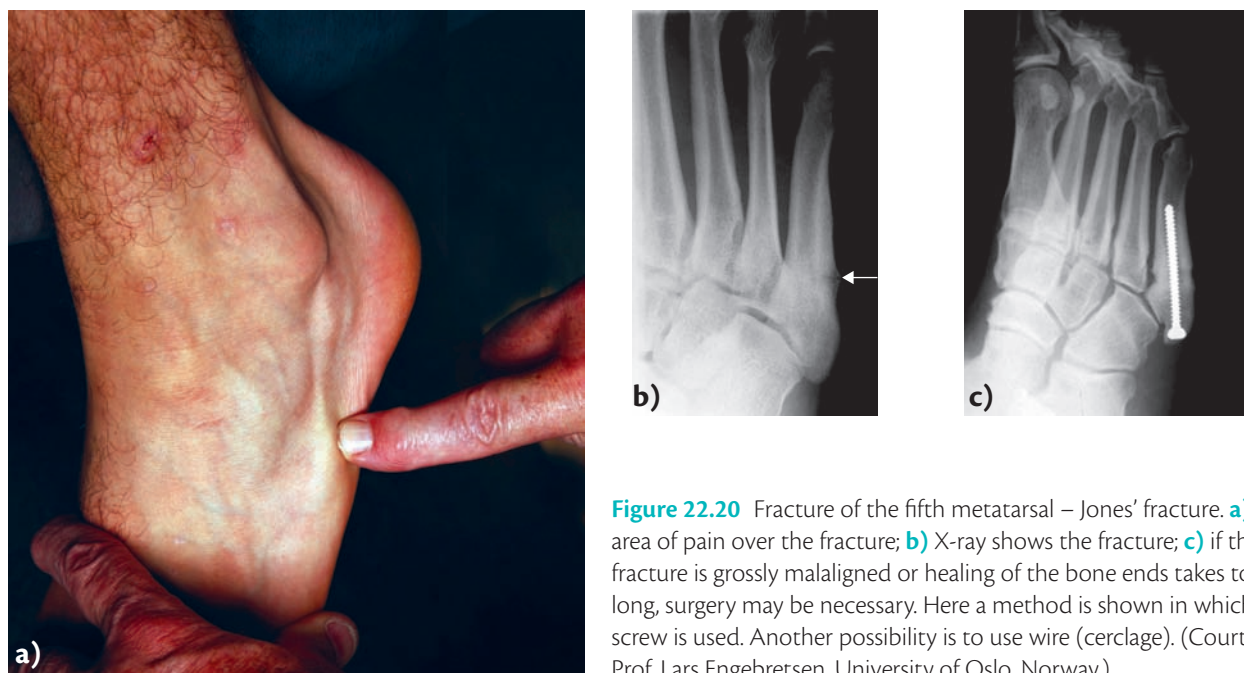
Fracture of the fifth metatarsal – Jones' fracture. a) Local area of pain over the fracture; b) X-ray shows the fracture; c) if the fracture is grossly malaligned or healing of the bone ends takes too long, surgery may be necessary. Here a method is shown in which a screw is used. Another possibility is to use wire (cerclage). (Courtesy of Prof. Lars Engebretsen, University of Oslo, Norway.)
